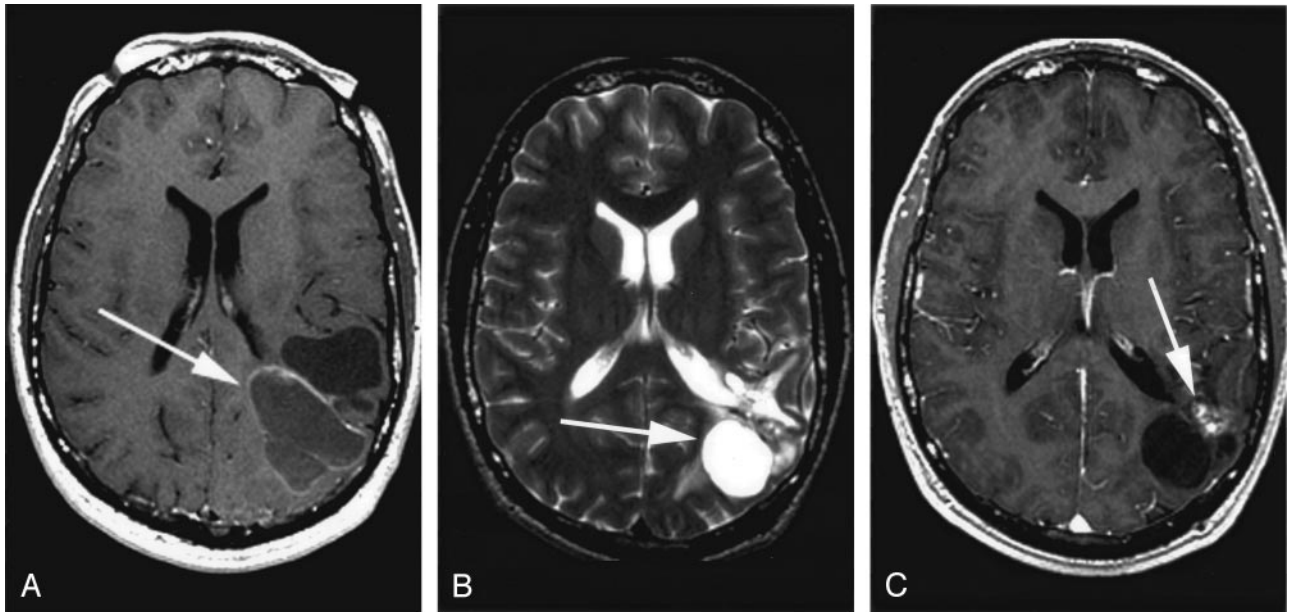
MR image obtained 36 months after AVM ablation.
